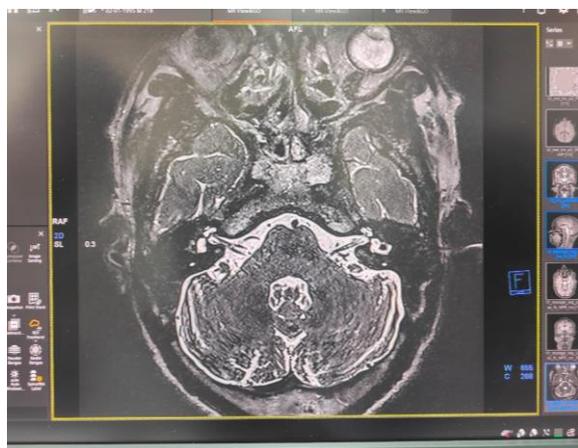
MRI of brain at the level exit of 7<sup>th</sup> CN.
